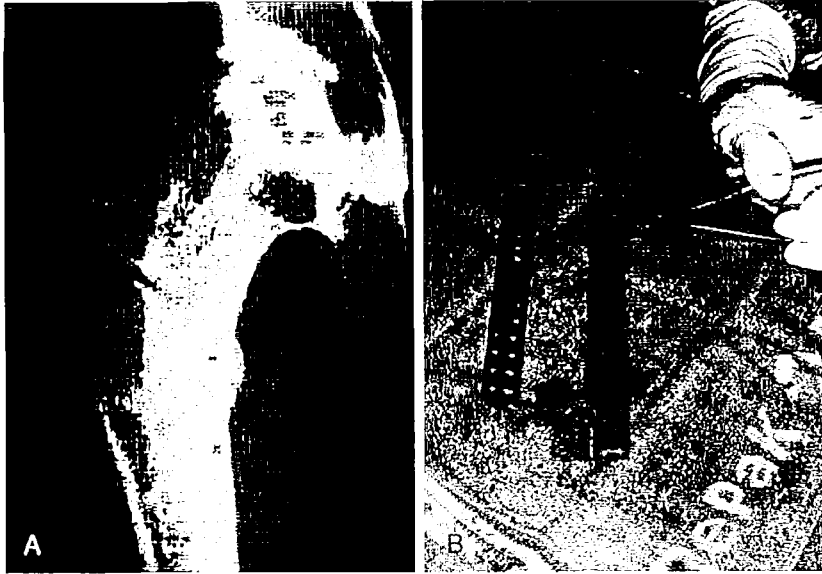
A, Plain radiograph of osteonecrosis of hip; Ficat stage II. B, Free vascularized fibular graft harvested.
